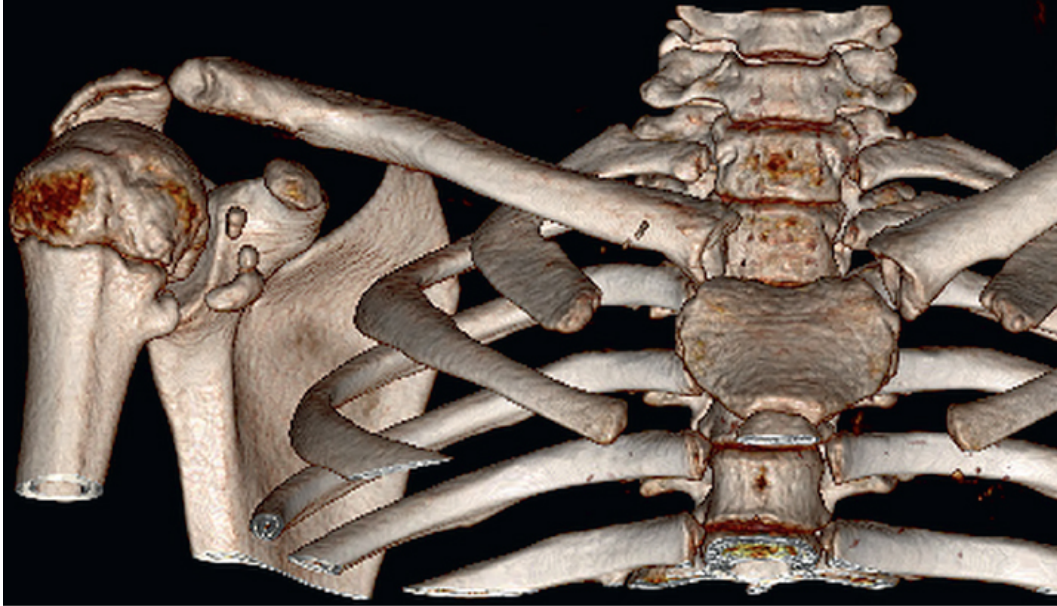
3D CT reconstructions better delineate the posterior and superior dislocation of the the right SC joint.
